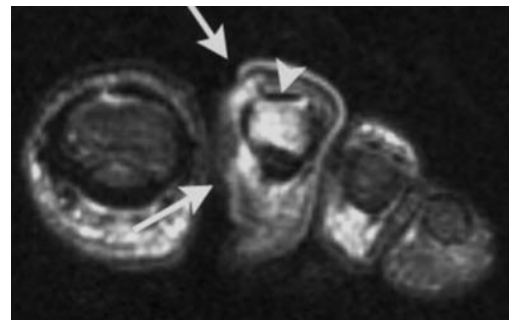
Coronal T2-weighted (T2W) scan
